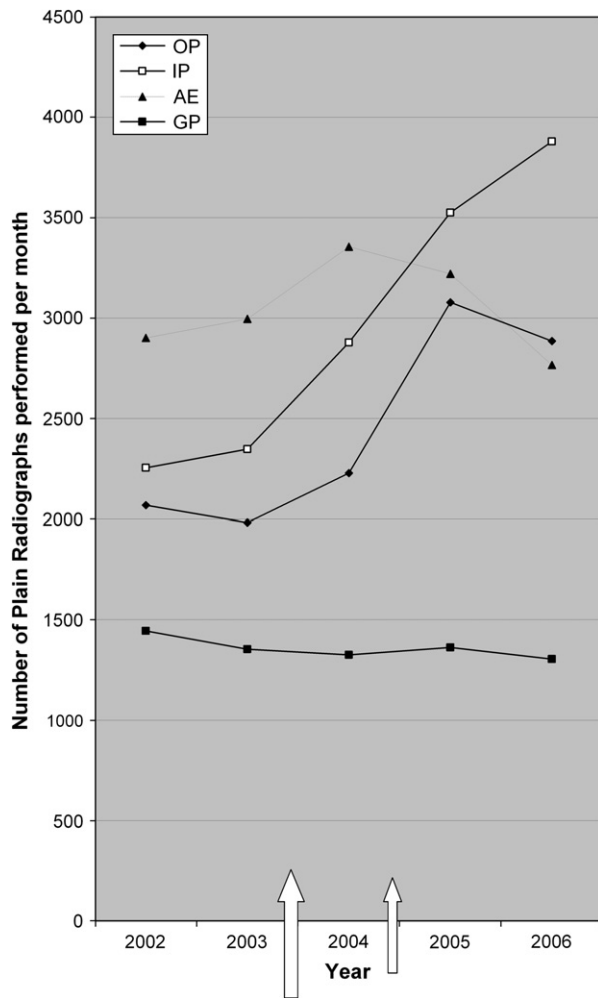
Number of plain radiographs performed per month 2002–2006. Large arrow: introduction of PACS; small arrow: introduction of digital dictation; OP, outpatients; IP, inpatients; AE, accident & emergency; GP, general practice.
